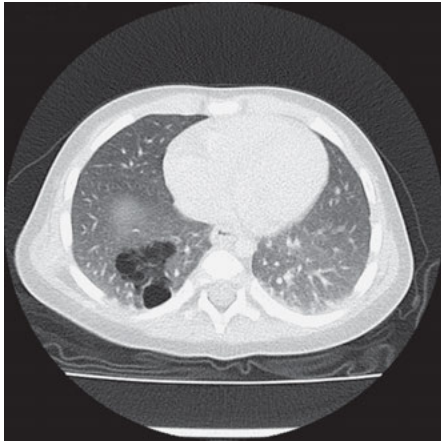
Chest CT of a 10-month-old girl with a CCAM type 2 in the right lower lobe. The malformation was diagnosed antenatally, and the girl was asymptomatic.
